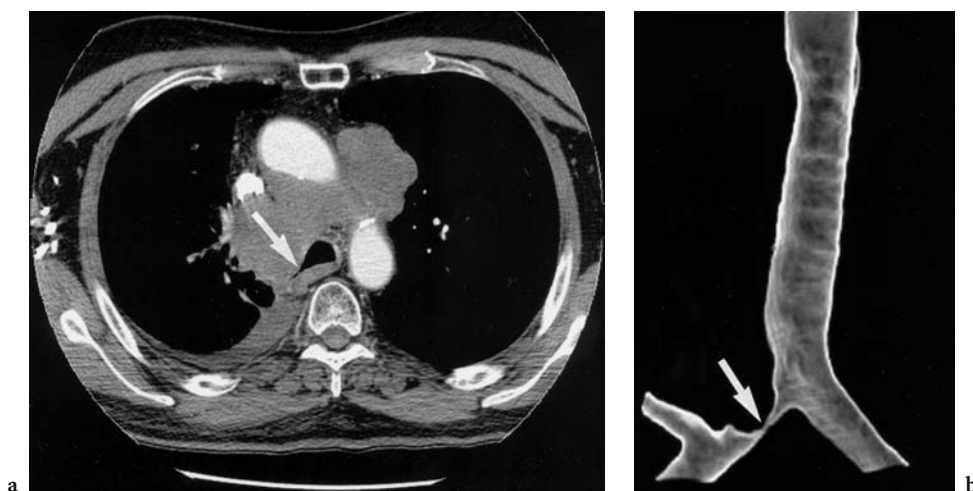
Improved assessment of central airway invasion with 3-D reconstruction image. a. Axial, contrast-enhanced CT at level of aorticopulmonary window shows large nodal mass compressing the carina. Origin of right mainstem bronchus (arrow) is severely narrowed but is difficult to fully assess because of its oblique orientation with respect to the axial plane. b. 3-D external volume rendering of airway reveals irregular deformity of distal trachea and carina, as well as severe narrowing of proximal right mainstem bronchus (arrow) with distal patency. Compared with axial images, the 3-D images provided a more accurate assessment of the overall extent of airway involvement (Reprinted with permission from BOISELLE et al. 2002)
